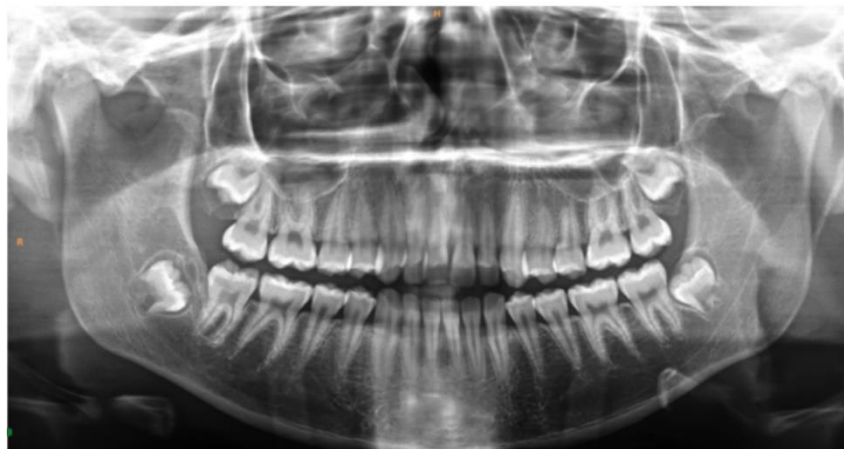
Panoramic radiograph obtained 17 months after lesion removal, showing eruption and continued development of tooth 48 (Nolla stage 6) associated with bone regeneration in the affected area.
